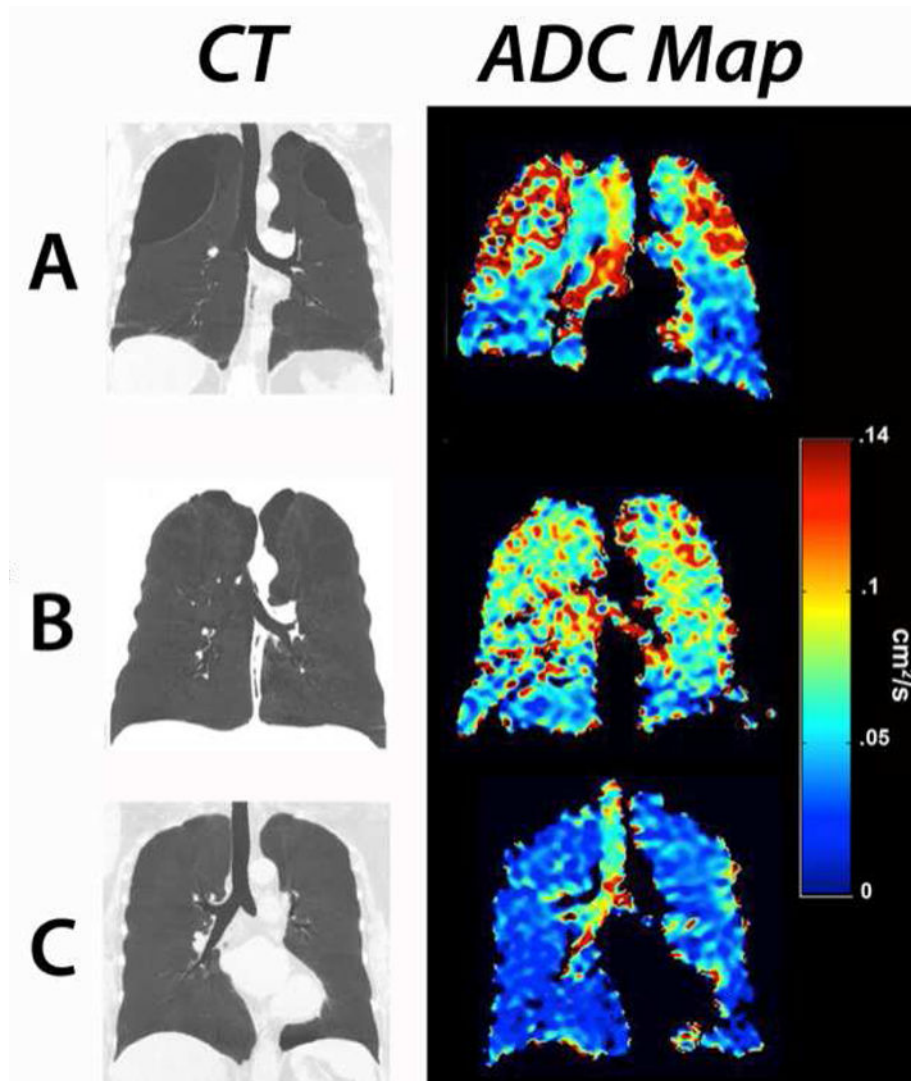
Apparent diffusion coefficient (ADC) MRI using HP ¹²⁹ Xe gas. The color scale shows escalating enlargement of airspaces from normal lung tissue (blue) to severe bullous emphysematous parenchymal destruction (red). Note parenchymal destruction depicted by CT paralleling the change of ADC values.
